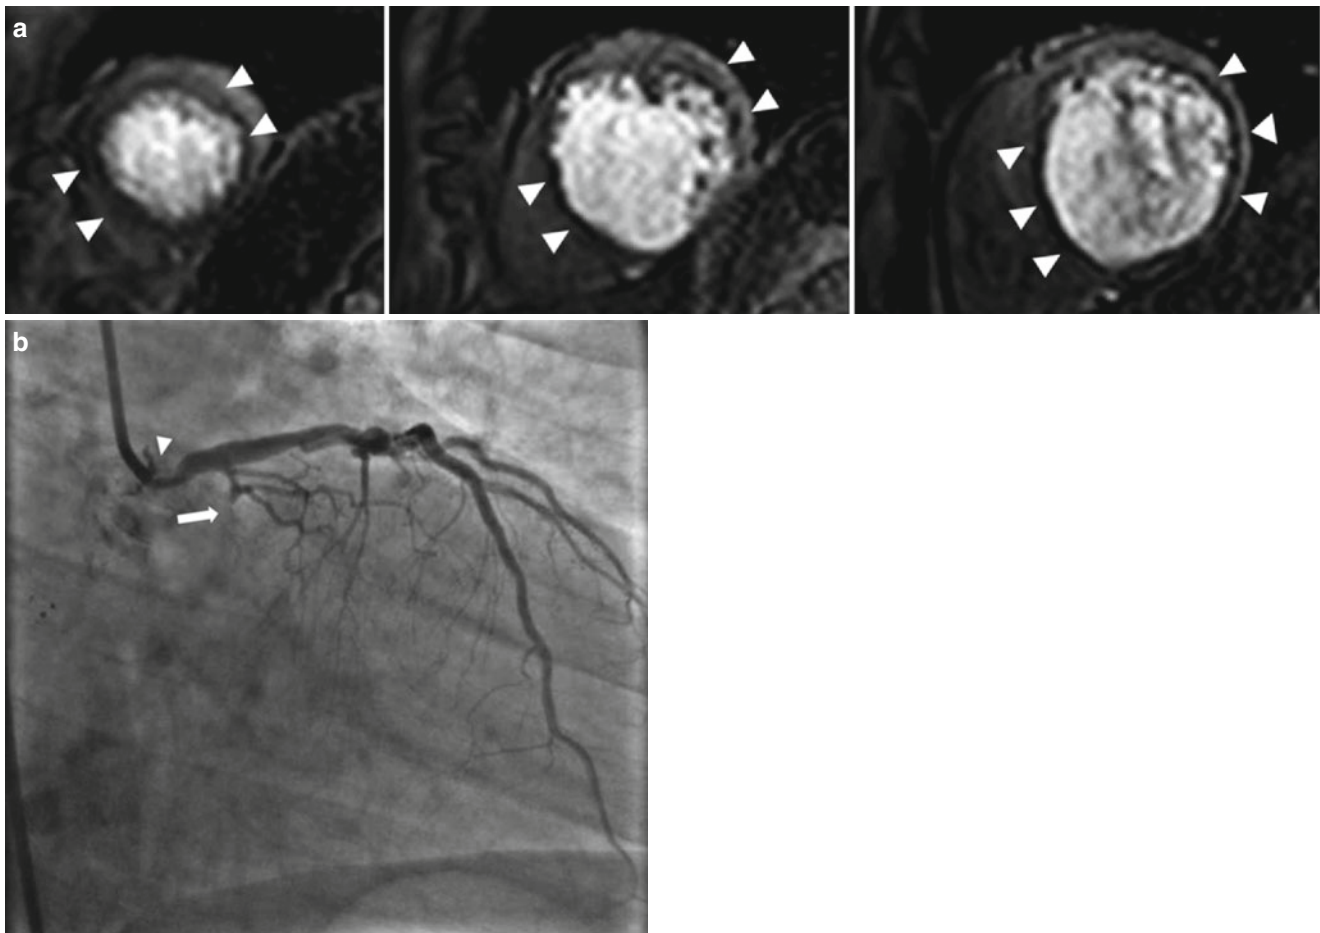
Vasodilator stress perfusion cardiac magnetic resonance image and the corresponding invasive angiogram. Images are from a 68-year-old man who presented with chest pain. (a) Stress perfusion study using adenosine revealed reversible hypoperfusion involving the left anterior descending (*arrowheads*) and left circumflex territories
